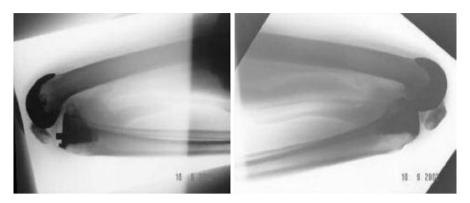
Lateral x-ray of the same patient, 3 months postoperatively
